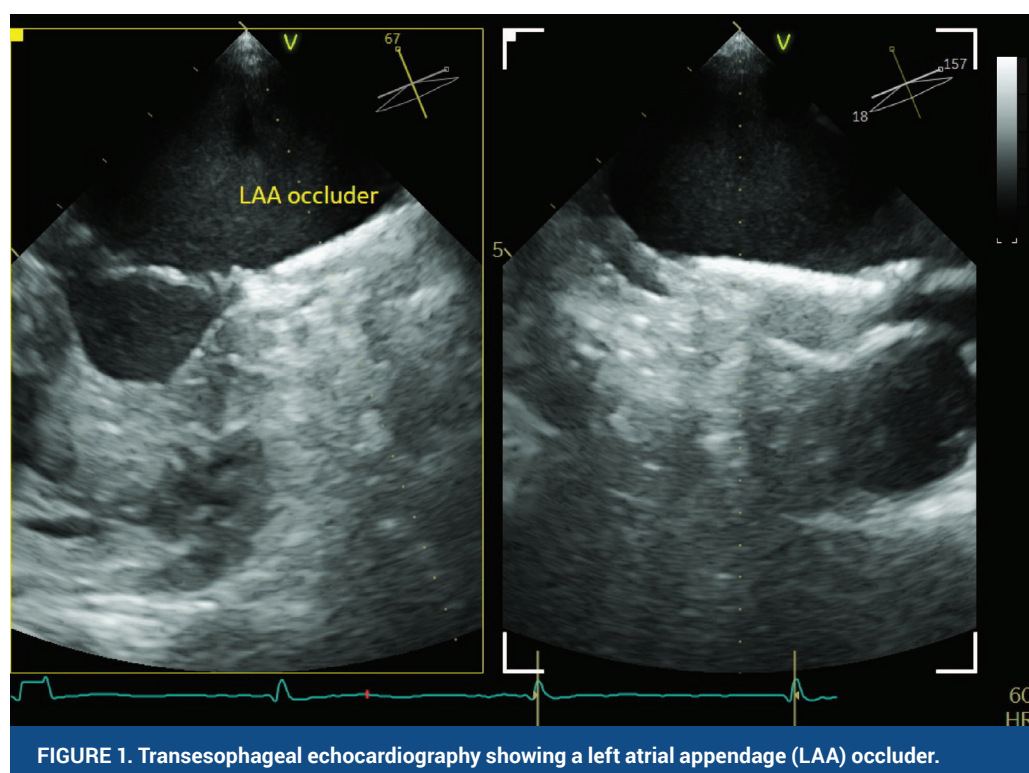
Transesophageal echocardiography showing a left atrial appendage (LAA) occluder.
